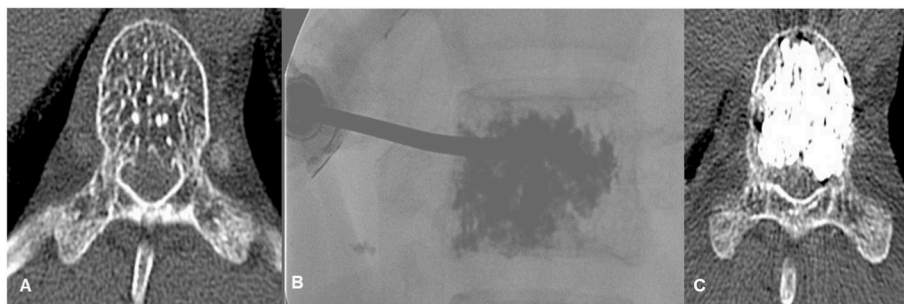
65-year-old male who had previously undergone alcohol injection presented with persistent symptoms at 6 months follow-up, A: His axial CT shows a lesion involving the T9 vertebral body having the characteristic “polka-dot” appearance. B: Fluoroscopy guided injection of bone cement into the lesion. C: Post-procedure CT showing the bone cement that is well contained within the lesion.
